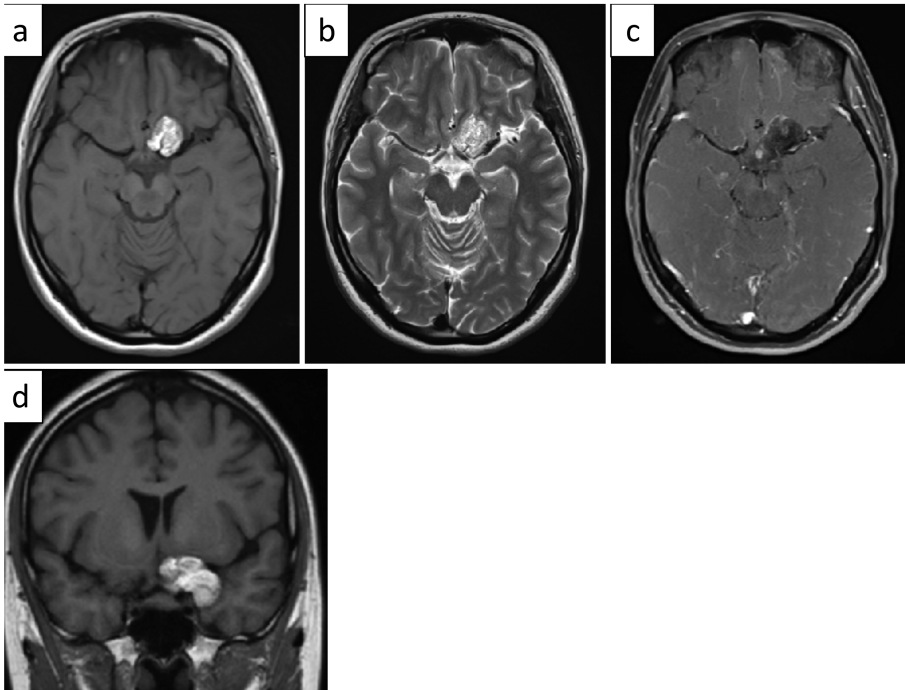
Preoperative magnetic resonance imaging (MRI)
